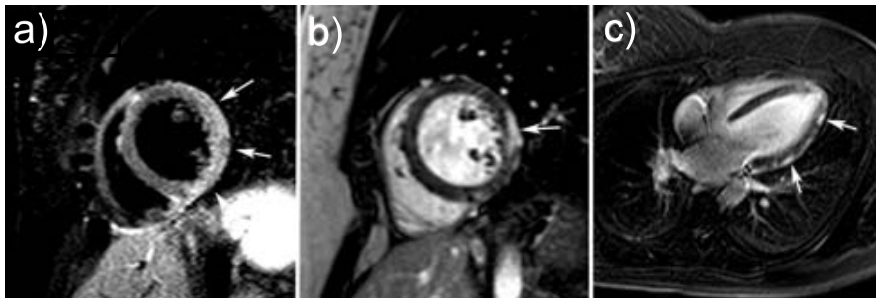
Reproduced from Florian et al.^[29]: MRI study in an 18 year old male with acute chest pain in which acute myocarditis was diagnosed. Mid ventricular short axis T2-weighted short-inversion-time inversion-recovery (T2w-STIR) image shows edema (increased signal intensities) in the lateral wall (arrows, a) and short and vertical long-axis ce-MRI show typical subepicardial enhancement in the lateral wall (arrows, b, c).
